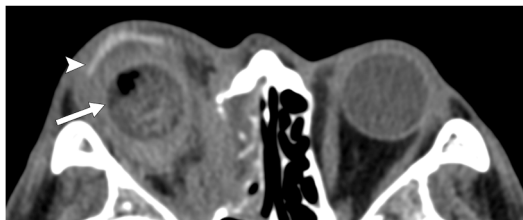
Axial CT of a recent right porous polyethylene implant appearing hypodense with internal air foci (white arrow). Right ocular prosthesis (arrowhead).
